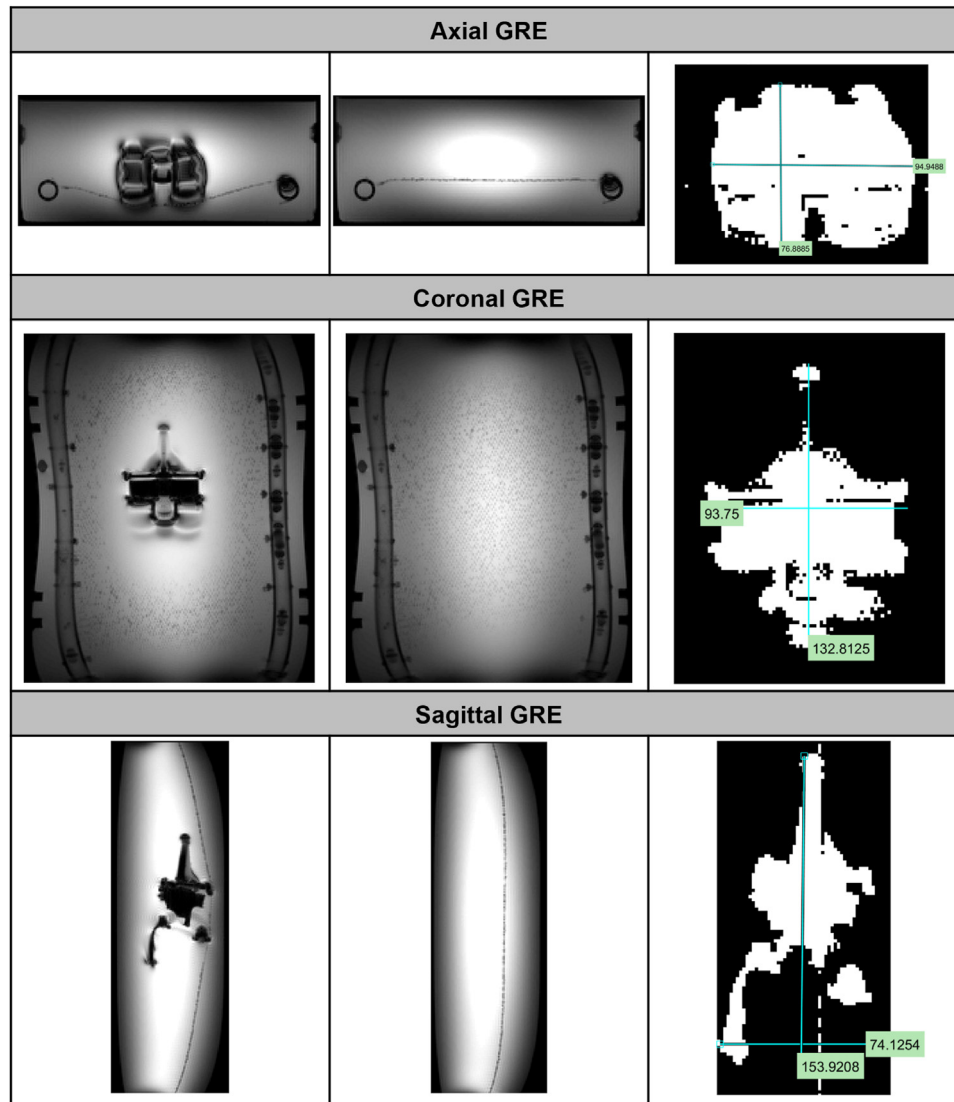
AMC ceramic knee with a gradient echo pulse sequence in a 3T MRI system. Worst-case image (left), background image (middle), resulting image artifact (right). Measurements are in millimeters.
